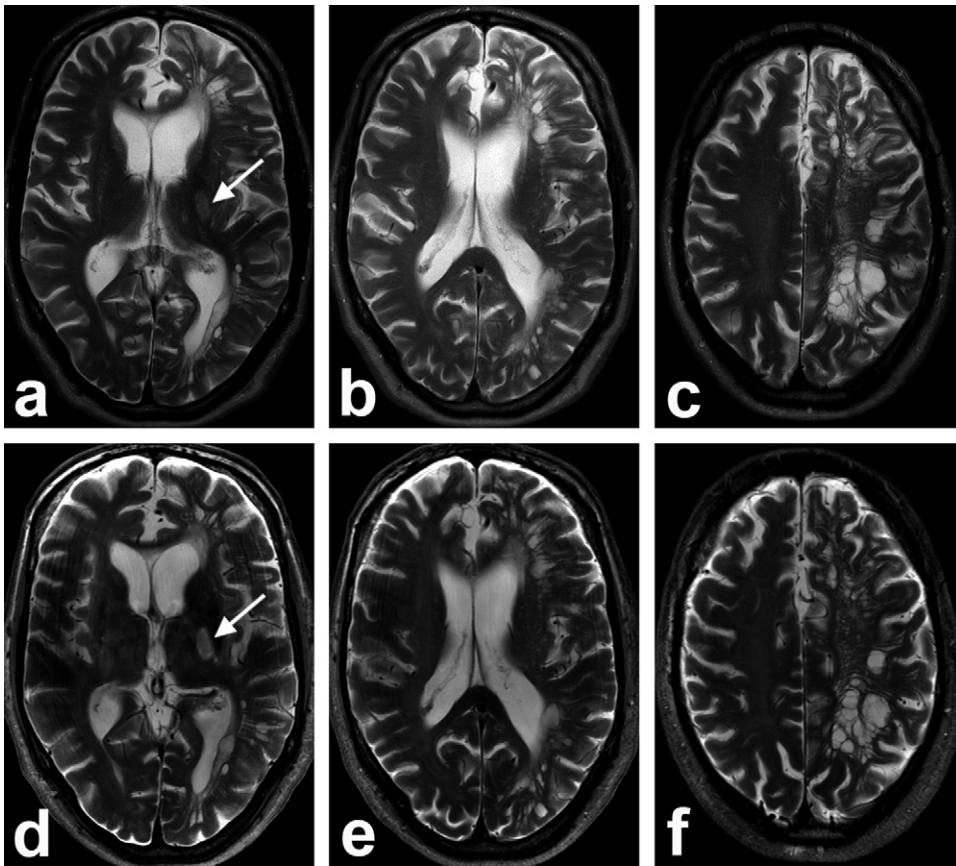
61-year-old male with a blank medical history presented with mild dysphasia and hemiparesis of his right arm and leg based on an ischemic stroke of the left hemisphere. a–c, Axial standard clinical 1.5T and d–f, 7T T_2 -weighted MR images, showing the ischemic area at the transition corona radiata – internal capsule (arrows in a and d), which can be more easily appreciated at the 7T images (d). Furthermore, several hyperintense structures can be seen on both 1.5 and 7T localized to the left hemisphere, consistent with enlarged perivascular spaces (a–f). Imaging parameters T_2 -weighted sequence: TR 5828 ms, TE 60 ms, 0.5 mm × 0.7 mm × 4.0 mm resolution.
